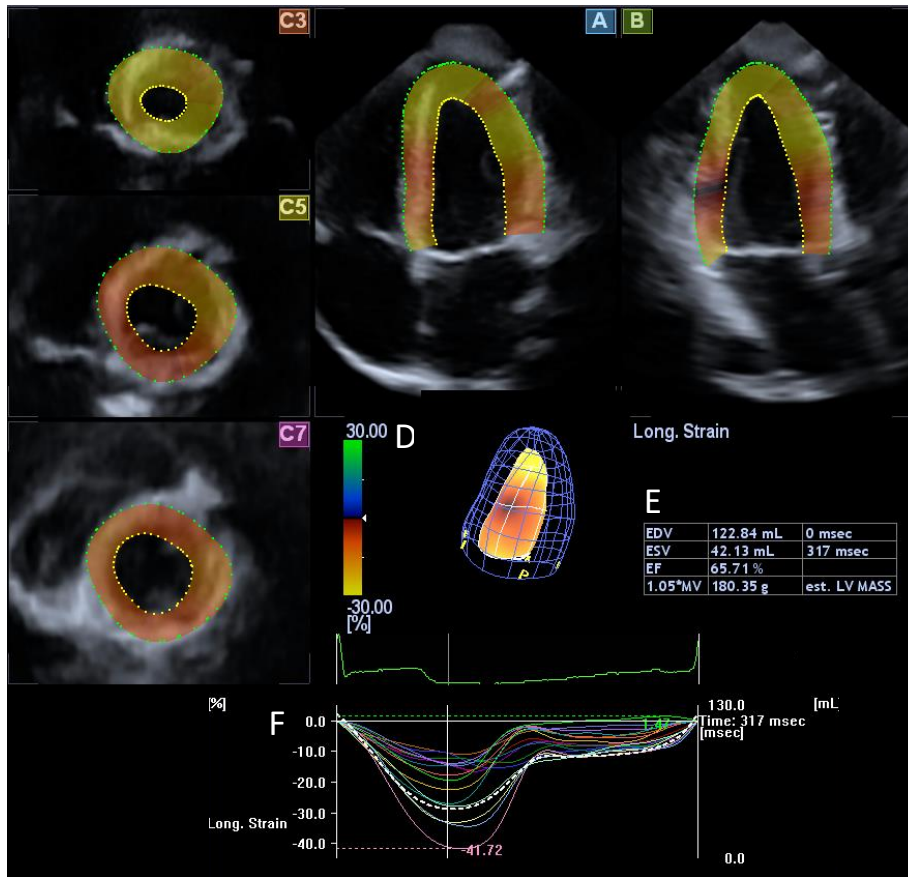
(left:) Apical 4-chamber (A) and 2-chamber (B) views and short-axis views (C3, C5, C7) at different levels of the left ventricle (LV) extracted from the three-dimensional (3D) echocardiographic dataset are presented. The 3D mesh model of the LV (D) and calculated LV volumetric data (E) are also shown. (right:) Images with normal LV rotational pattern with counterclockwise apical (white arrow) and clockwise basal rotations (dashed arrows)(F), apical LV hyporotation (G) and the near absence of LV twist called as LV rigid body rotation with LV apical and basal rotations in the same direction (H) are presented
